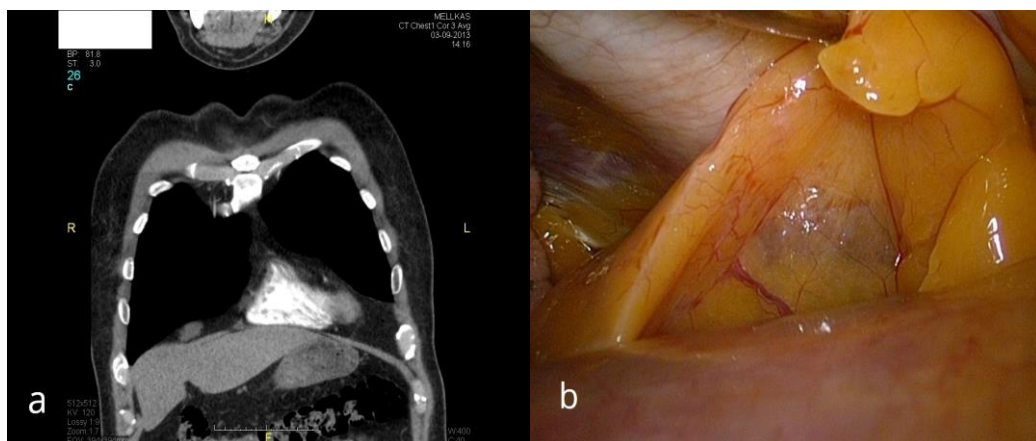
ETT in the right pericardio-phrenic fat, a: chest CT, b: intraoperative picture
